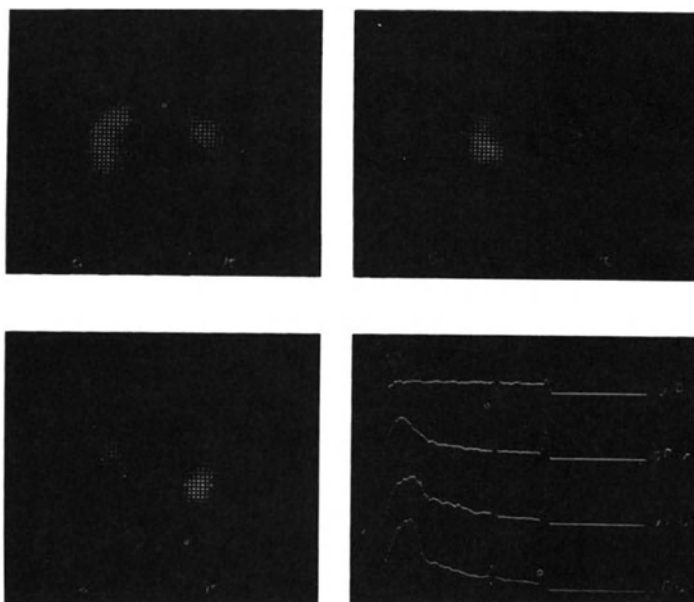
Renal phase scintigram for studying the clearance of renal segments.
